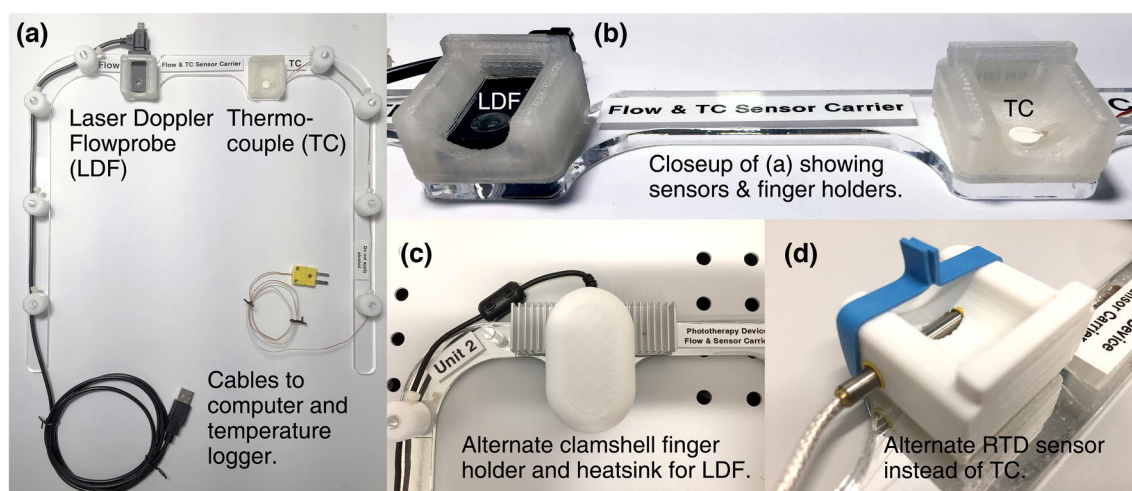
Photographs of a removable sensor carrier, b closeup of a showing the laser doppler flowmeter (LDF) and thermocouple sensors, and finger holders, c optional clamshell-style LDF sensor holder
